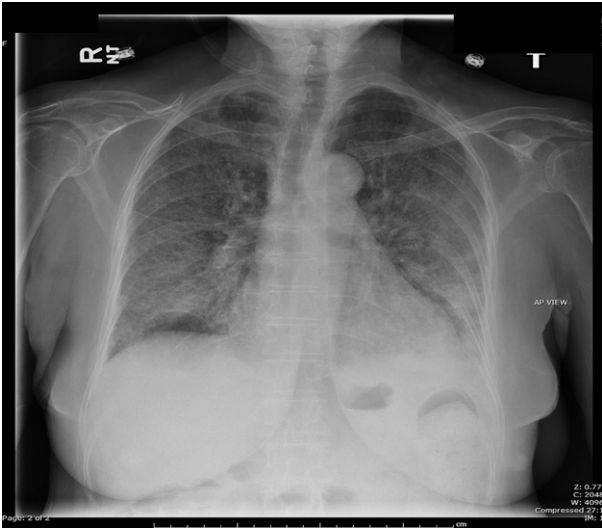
AP chest X-ray demonstrating diffuse patchy opacification.
